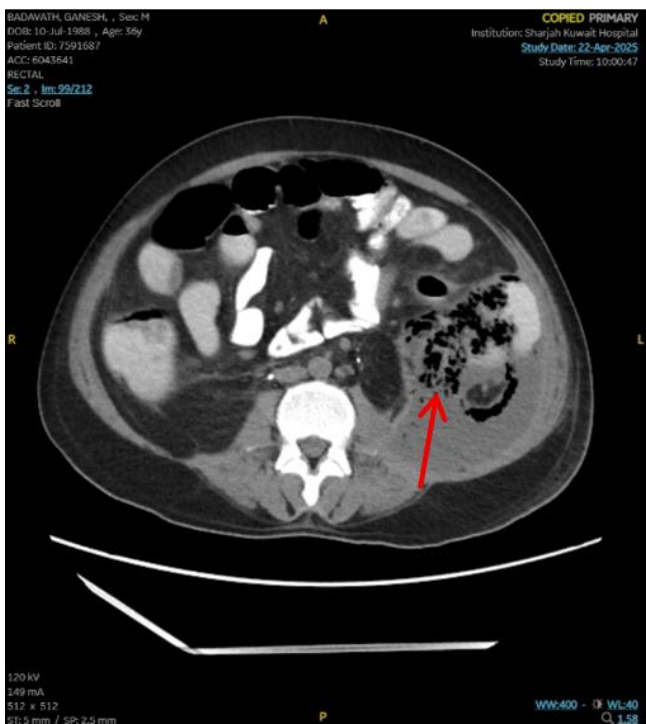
CT scan revealing Mottled gas within the retroperitoneal collection extending from the pancreatic tail region to the pelvis could be due to colonic communication
